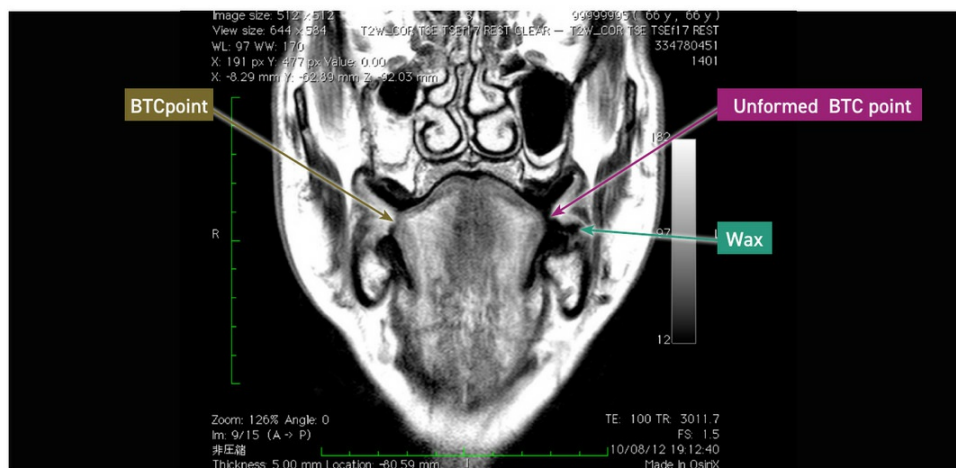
MRI also demonstrates that the utility wax prevents BTC Point formation on the overextended side.
